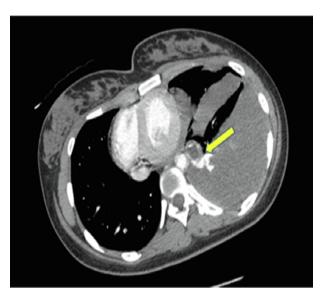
Chest computed tomography showing left hemothorax due to the ruptured metastatic mole.
